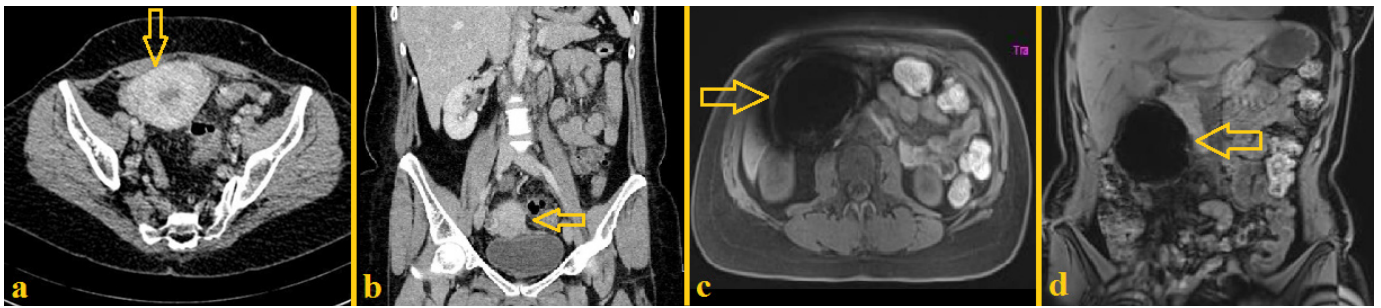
Image studies performed on a patient with GCD. a, b) CT-scan disclosing a pelvic cystic mass with wall thickening, fat stranding and communication with the sigmoid colon (yellow arrows): a) axial plane; b) coronal plane. c, d) Contrast enhanced MRI performed 2 months after initial presentation disclosing cranial displacement, enlargement, reduction of wall thickening and fat stranding of the GCD (yellow arrows): c) axial plane; d) coronal plane.
